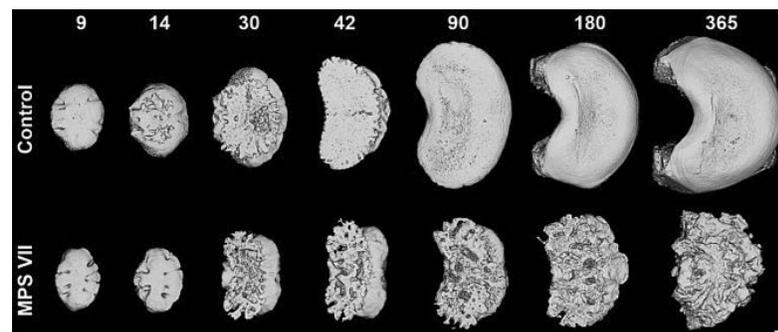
Representative axial μ CT images showing delayed, incomplete, and non-uniform progression of secondary ossification in MPS VII vertebrae compared to controls. Numbers indicate postnatal days-of-age. Scale = 1mm.
